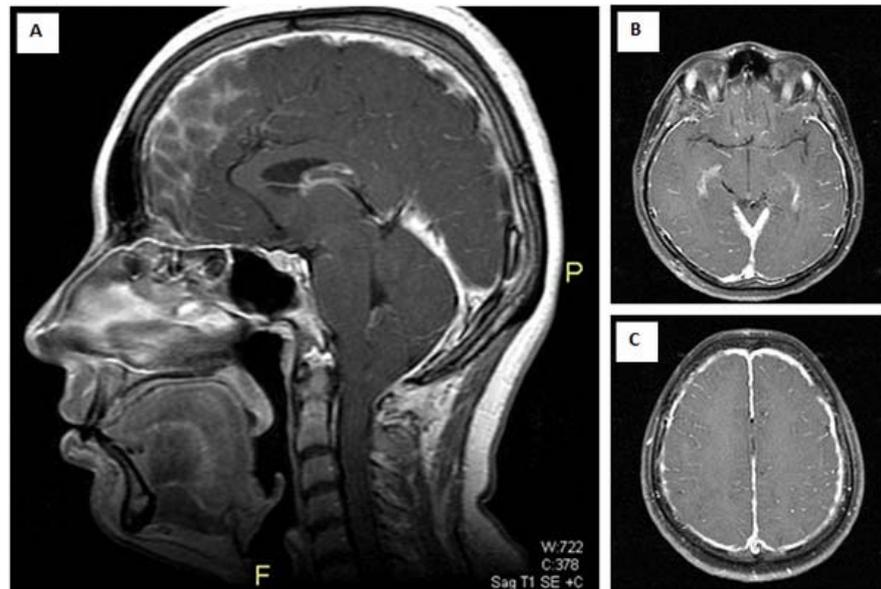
(A) Sagittal, T1- weighted post-contrast MRI image shows displacement of cerebellar tonsils 10 mm inferior through the foramen magnum. Partial empty sella appearance is not persisting, and the height of the sella is in normal ranges, (B, C) Axial T1- weighted MRI image shows diffuse dural thickening and enhancement.
